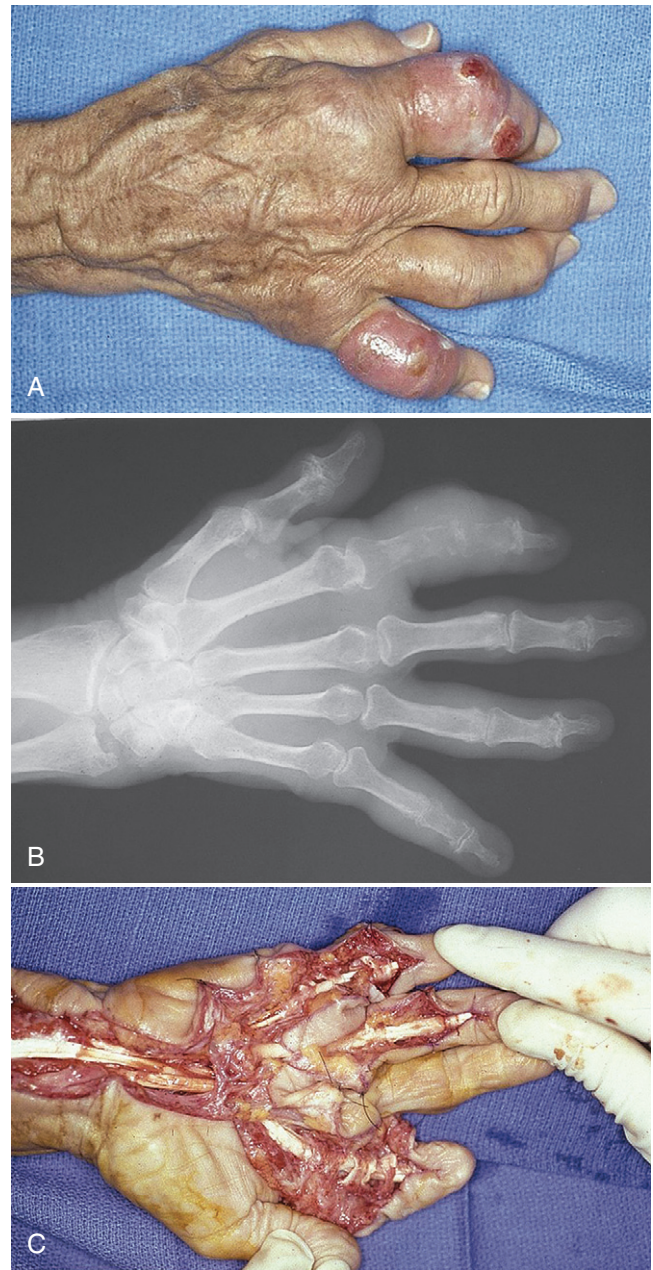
A, Hand demonstrating tenosynovitis and synovitis secondary to *Mycobacterium marinum*. B, Radiograph of the hand in A demonstrates joint destruction secondary to *M. marinum*. C, Hand depicted in A and B shows extensive tenosynovitis at the time of synovectomy.
